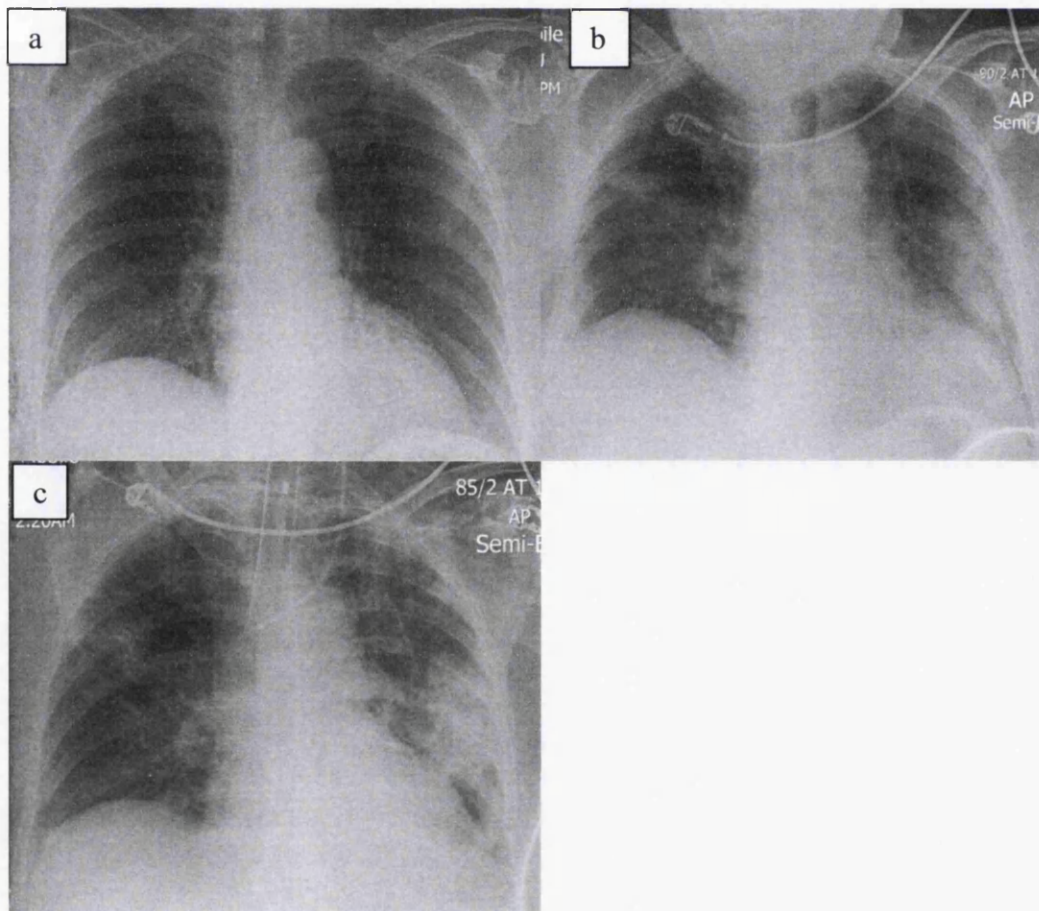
Series of chest radiographs highlighting the on-set of pneumonia and in a patient with blunt chest wall trauma. CXR a) Right side rib fractures with surgical emphysema on the initial day of presentation to the ED. CXR b) Early
